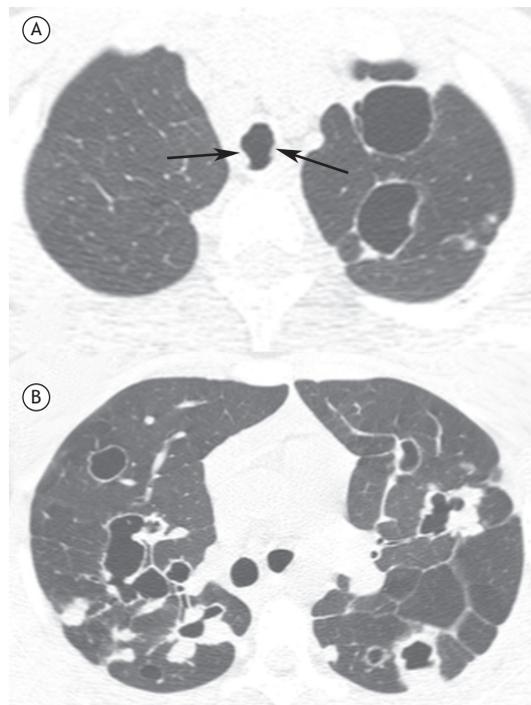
Axial CT scans at the level of the upper lobes (in A) and below the bronchial bifurcation (in B), showing solid and cavitated nodules in both lungs, with thick or thin walls. Nodular formations are also observed in the walls of the trachea (arrows).
